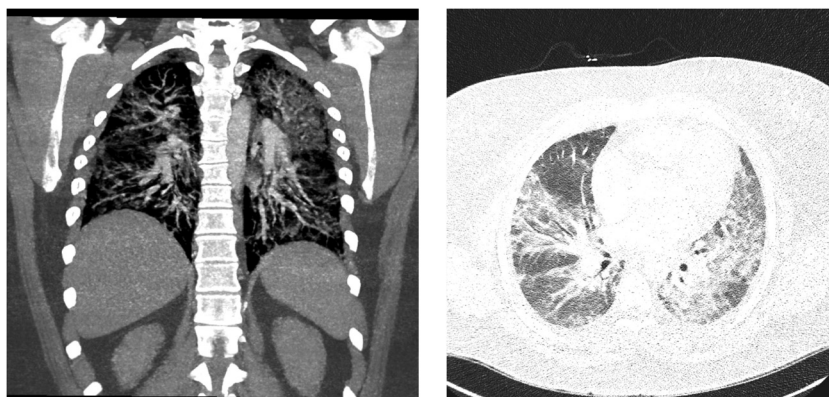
Chest CT scan on presentation showing bilateral infiltrates. Left: coronal view; right: axial view.
